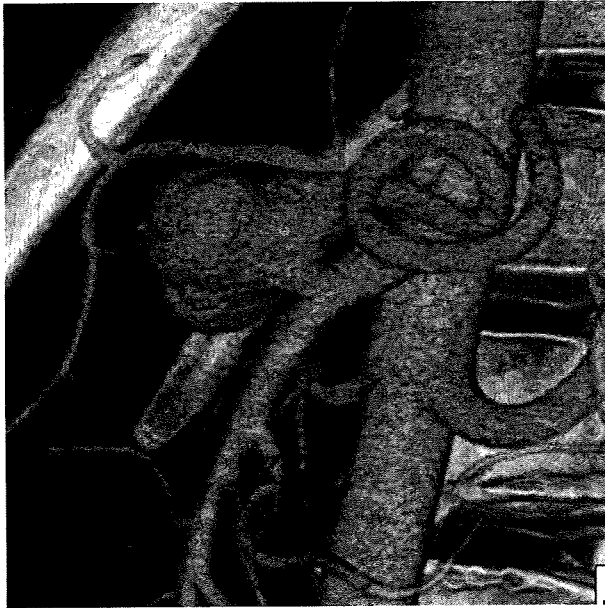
Three-dimensional reconstructed image based on contrast medium-enhanced computed tomographic scans obtained using a 16-detector CT. The splenic artery originating from the SMA and a saccular aneurysm in the splenic artery immediately distal to the origin can be seen.
